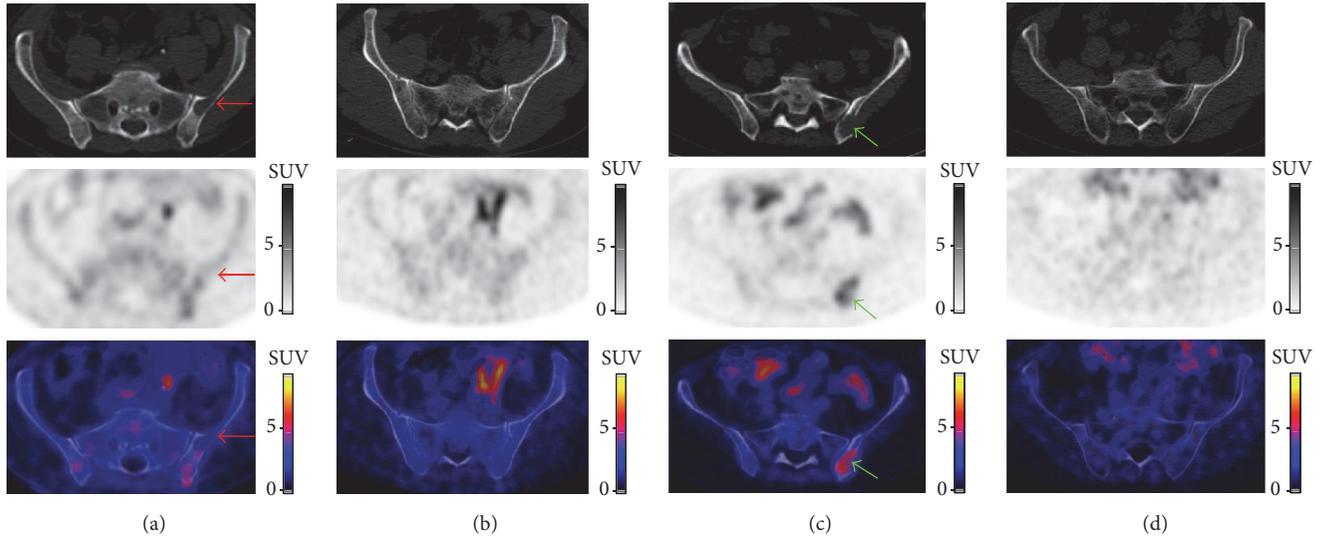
$[^{18}\text{F}]\text{FPRGD}_2$ PET/CT images of all patients. A diffuse bone marrow involvement was described based on CT images in patients #1 (a) and #2 (b); the $[^{18}\text{F}]\text{FPRGD}_2$ PET images also showed diffuse and heterogeneous bone marrow $[^{18}\text{F}]\text{FPRGD}_2$ uptake in patients #1 (a) and a mild diffuse bone marrow uptake in patient #2 (b). In contrast, no diffuse bone marrow $[^{18}\text{F}]\text{FPRGD}_2$ uptake was seen in patients #3 ((c) the green arrows point at a lytic FL with $[^{18}\text{F}]\text{FPRGD}_2$ uptake) and #4 ((d) no lesion shown). Note that, in patient #1 (a) with newly diagnosed MM, a large osteolytic FL in CT images did not show $[^{18}\text{F}]\text{FPRGD}_2$ uptake above the bone marrow background ((a) red arrows).
